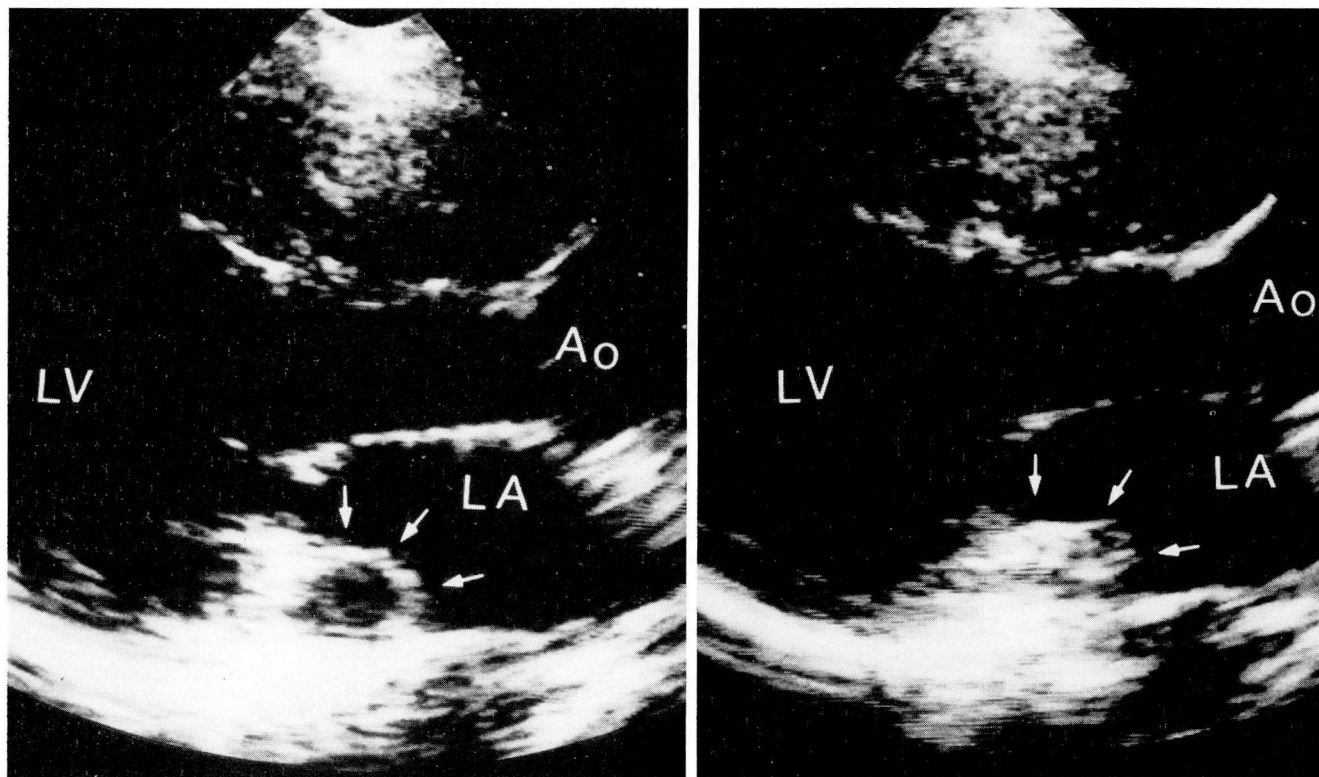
A. Parasternal long axis view showing dilated coronary sinus (arrows) of a patient with a persistent left superior vena cava.
